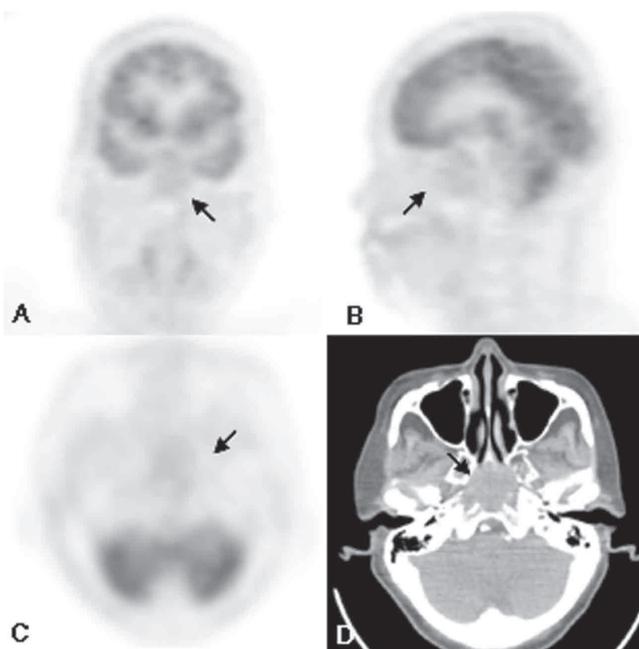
The FDG PET images of a 72-year-old female patient (patient #11) who was confirmed of metastasis in her sphenoid sinus 2.5 months after her PET study. Mild, diffuse FDG uptake with SUV equaled to 2.6 in the sphenoid sinus. This image was diagnosed as PET negative.
